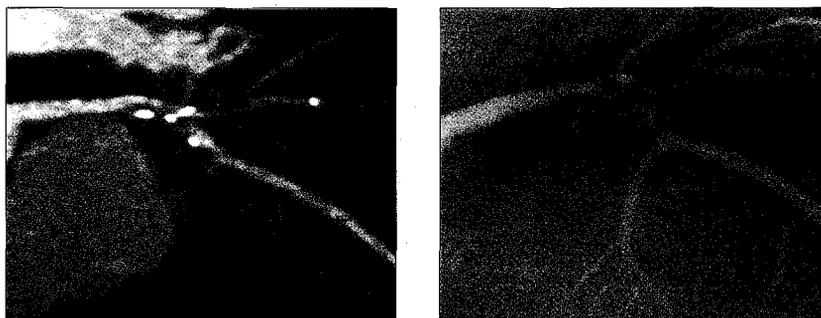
CTA (top) and CCA (bottom – reversed contrast) of a 39-year gentleman presenting with angina post-infarction. Both images reveal a tight (up to 95%) stenosis in the proximal LAD segment involving the ostium of the 1st diagonal branch.
